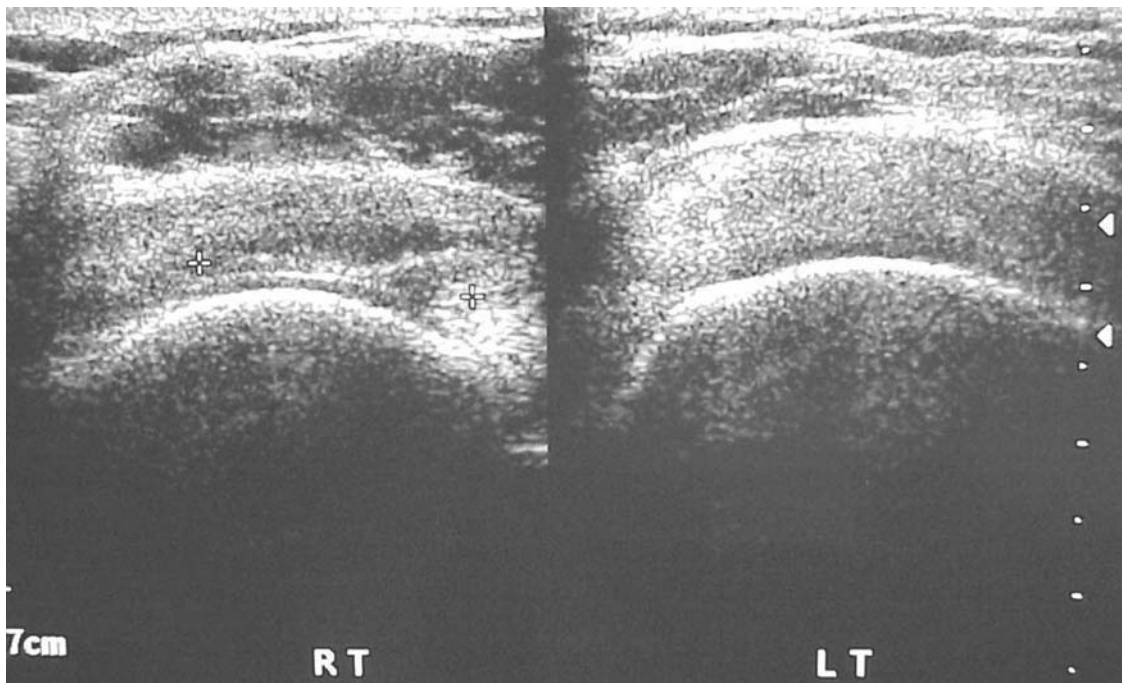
Transverse ultrasound of the supraspinatus tendon of both shoulders. The left is normal. The right has a full thickness tear between the asterisks.
